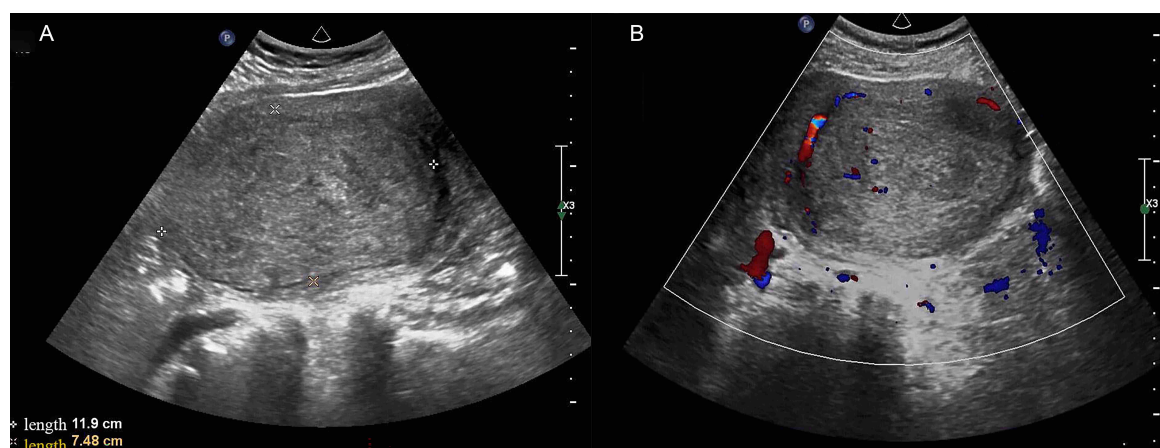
Images of ultrasonic examination of UTROSCT. (A) Transvaginal ultrasonography showed a hypoechoic mass ($7.5 \times 7.8 \times 11.9$ cm) located at the fundus of uterine with distinct border. (B) The color flow imaging displayed striped blood flow signals around the mass.
